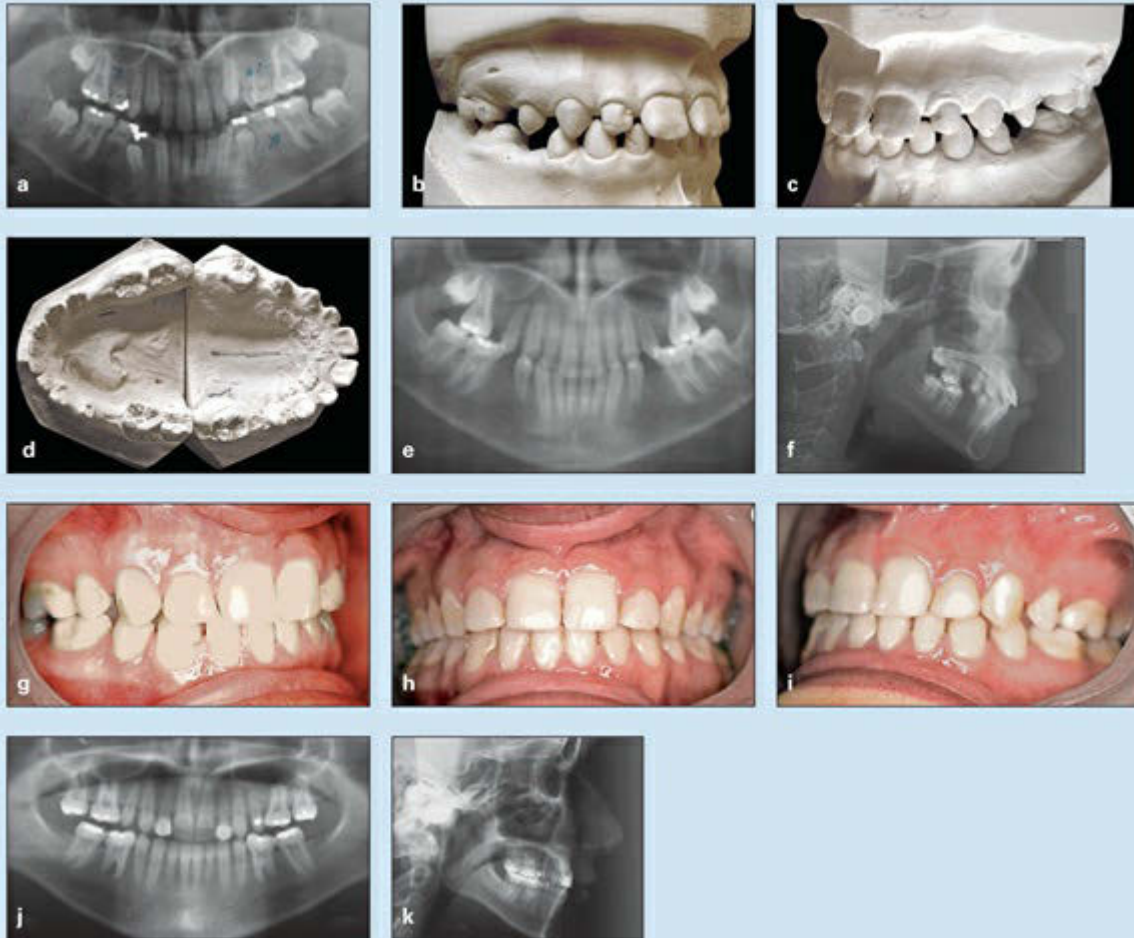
Treatment of a 14-year-old girl with oligodontia. All second premolars and third molars are missing. She also exhibits microdontia and interdental spacing. (a) Pretreatment panoramic radiograph taken 3 years before orthodontic referral. (b to d) Pretreatment casts of the occlusion. (e) Pretreatment panoramic radiograph, taken at the time of orthodontic referral. (f) Pretreatment cephalometric radiograph. (g to i) Posttreatment occlusion. All spaces are closed, and the soft tissue profile is improved. (j) Posttreatment panoramic radiograph. (k) Posttreatment cephalometric radiograph.
